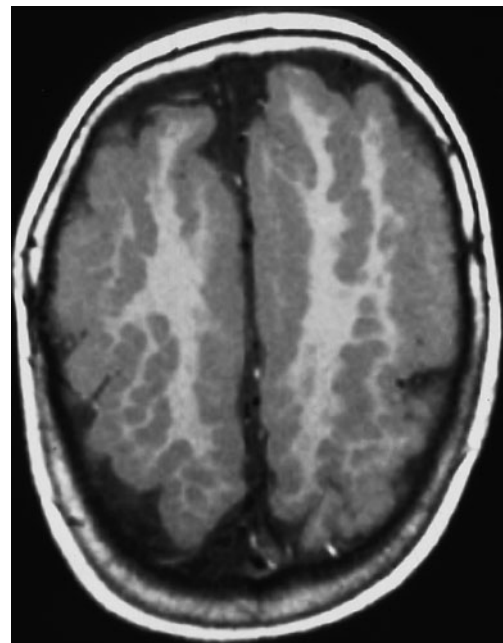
Axial T1-weighted image shows diffuse coarse PMG with an appearance of “palisades” of cortex
